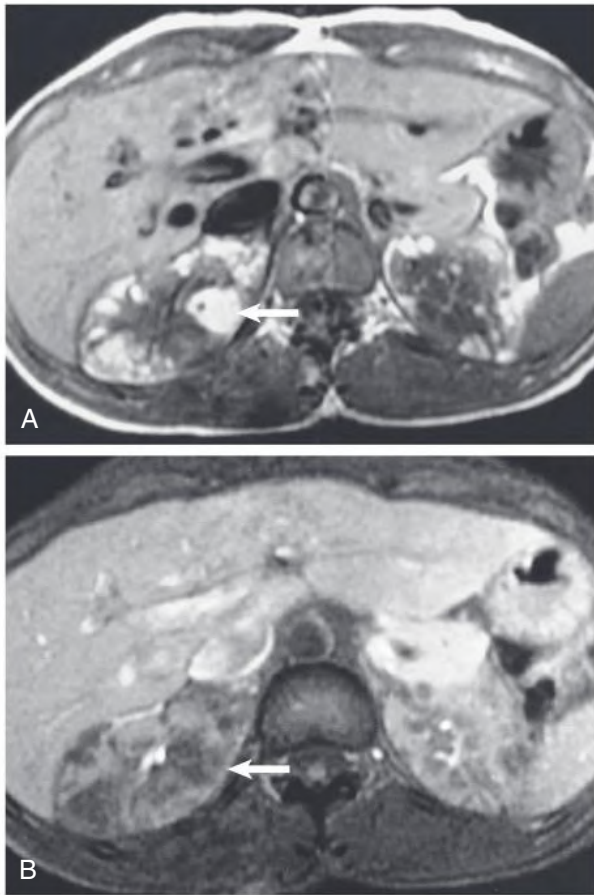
Tuberos Sclerosis on Magnetic Resonance (MR) Imaging. Multiple renal angiomyolipomas are seen. (A) T1-weighted MR image. The tumors are high in signal on T1 because of their fat; *arrow* shows the largest tumor. (B) T1-weighted MR image with fat suppression. The fat within the tumors is now low in signal (*arrow*).
